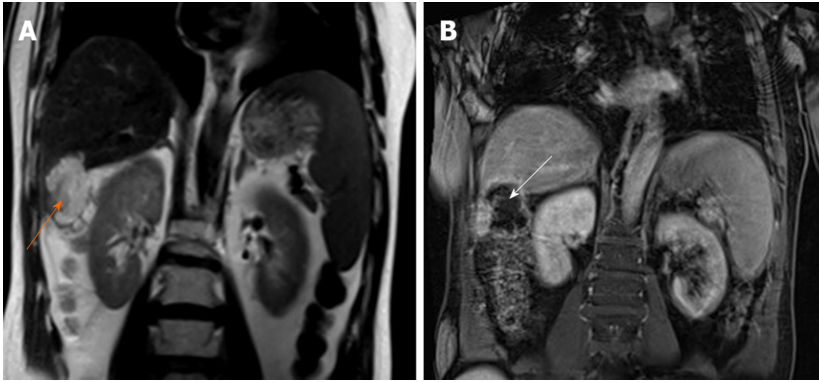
Magnetic resonance imaging after 3 mo. A: A magnetic resonance T2 weighted image coronal image showed that the lesion was larger than before, and the border between the lesion and colonic liver curvature was unclear (orange arrow); B: A magnetic resonance T1 weight image coronal image (white arrow).
